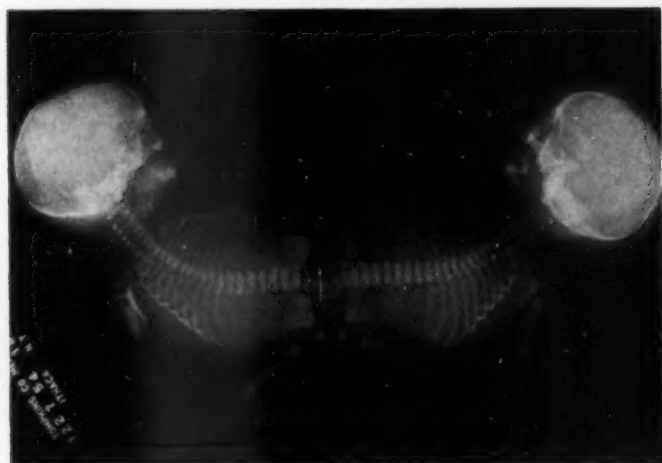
Roentgenogram showing relationships of vertebral columns. Note that the coccyx of each twin points to the same side of the body.
